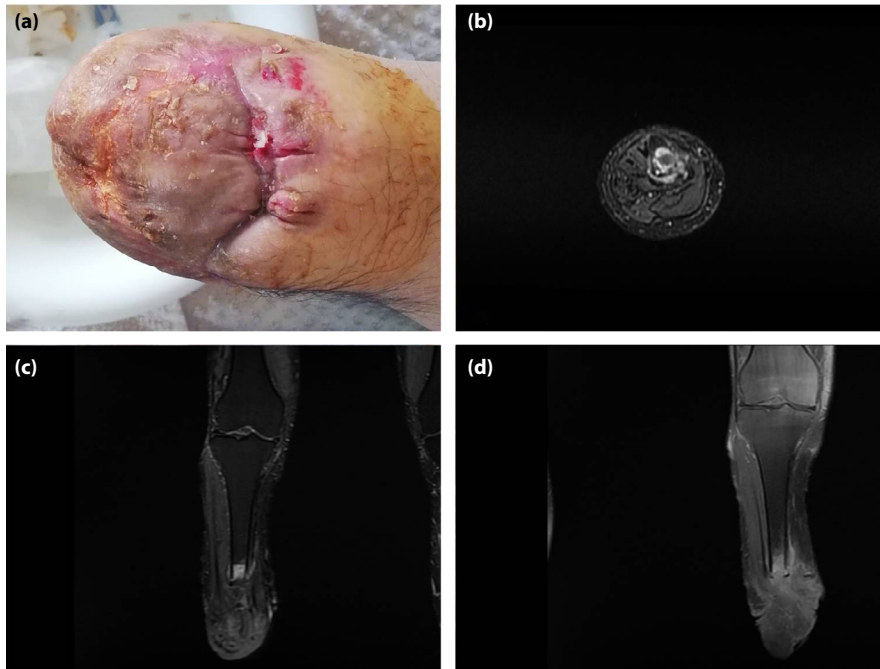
(a) The residual limb after the removal of the stitches with no signs of phlogosis and purulent discharge. (b,c) Significant volumetric reduction of the hyperintense signal of the tibia and the soft tissues in axial and coronal short tau inversion recovery magnetic resonance imaging sequences. (d) Reduction of the contrast impregnation of the tibia and the soft tissues in coronal T1-weighted FS sequence after gadolinium administration.
